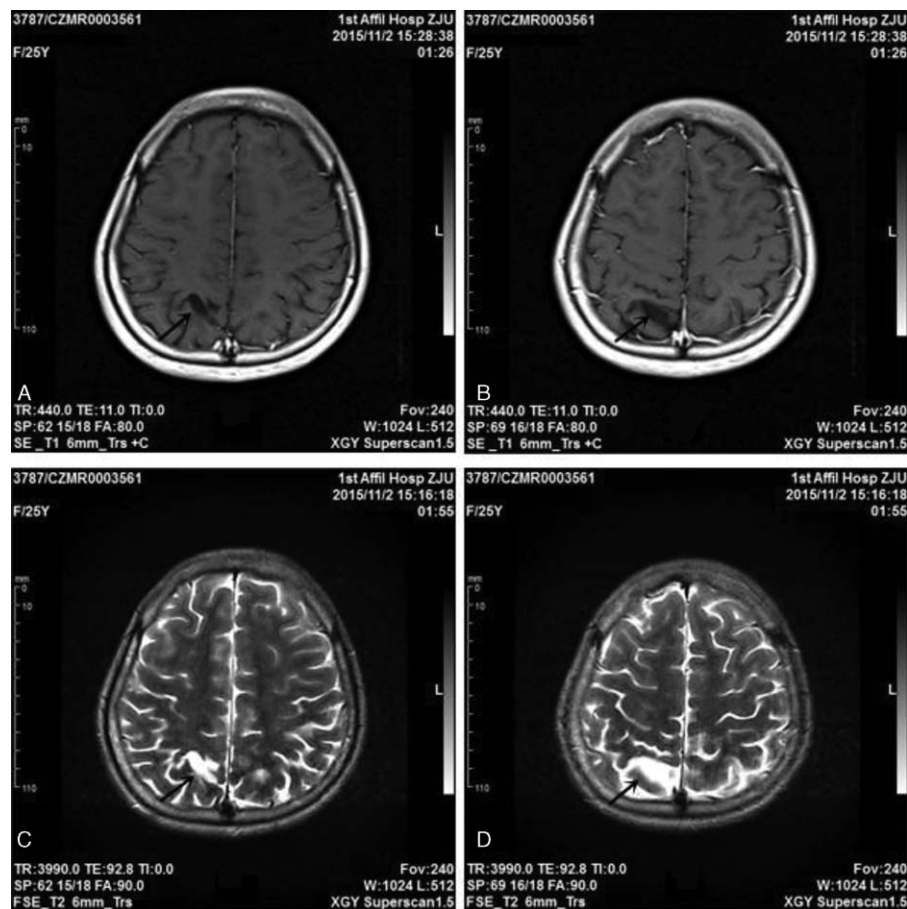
(A, B) T1 cranial magnetic resonance imaging (MRI) scan shows an abnormal signal in the gray and white matter junction of the parietal lobe. (C, D) T2-weighted cranial MRI scan indicates a focal lesion in the right parietal lobe with abnormally increased intensity, which was believed to be encephalomalacia. (A–D) Given her age, the sulci were widened and the gyri were shrunk, which suggests slight brain atrophy.
